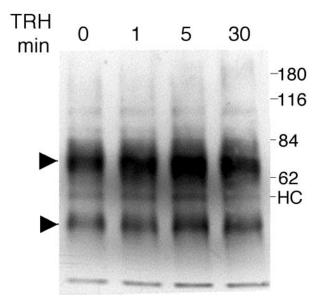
Dimerization and phosphorylation of the carboxyl-terminally truncated mutant TRH receptor. Monolayers of HEK293 cells stably expressing HA-tagged CT-TRH receptors were stimulated with 1 μ M TRH for 0, 1, 5, or 30 min. Cells were then lysed, immunoprecipitated and immunoblotted with HA11 anti-HA antibody. *Arrowheads* denote TRH receptors. *HC*, heavy chain.
